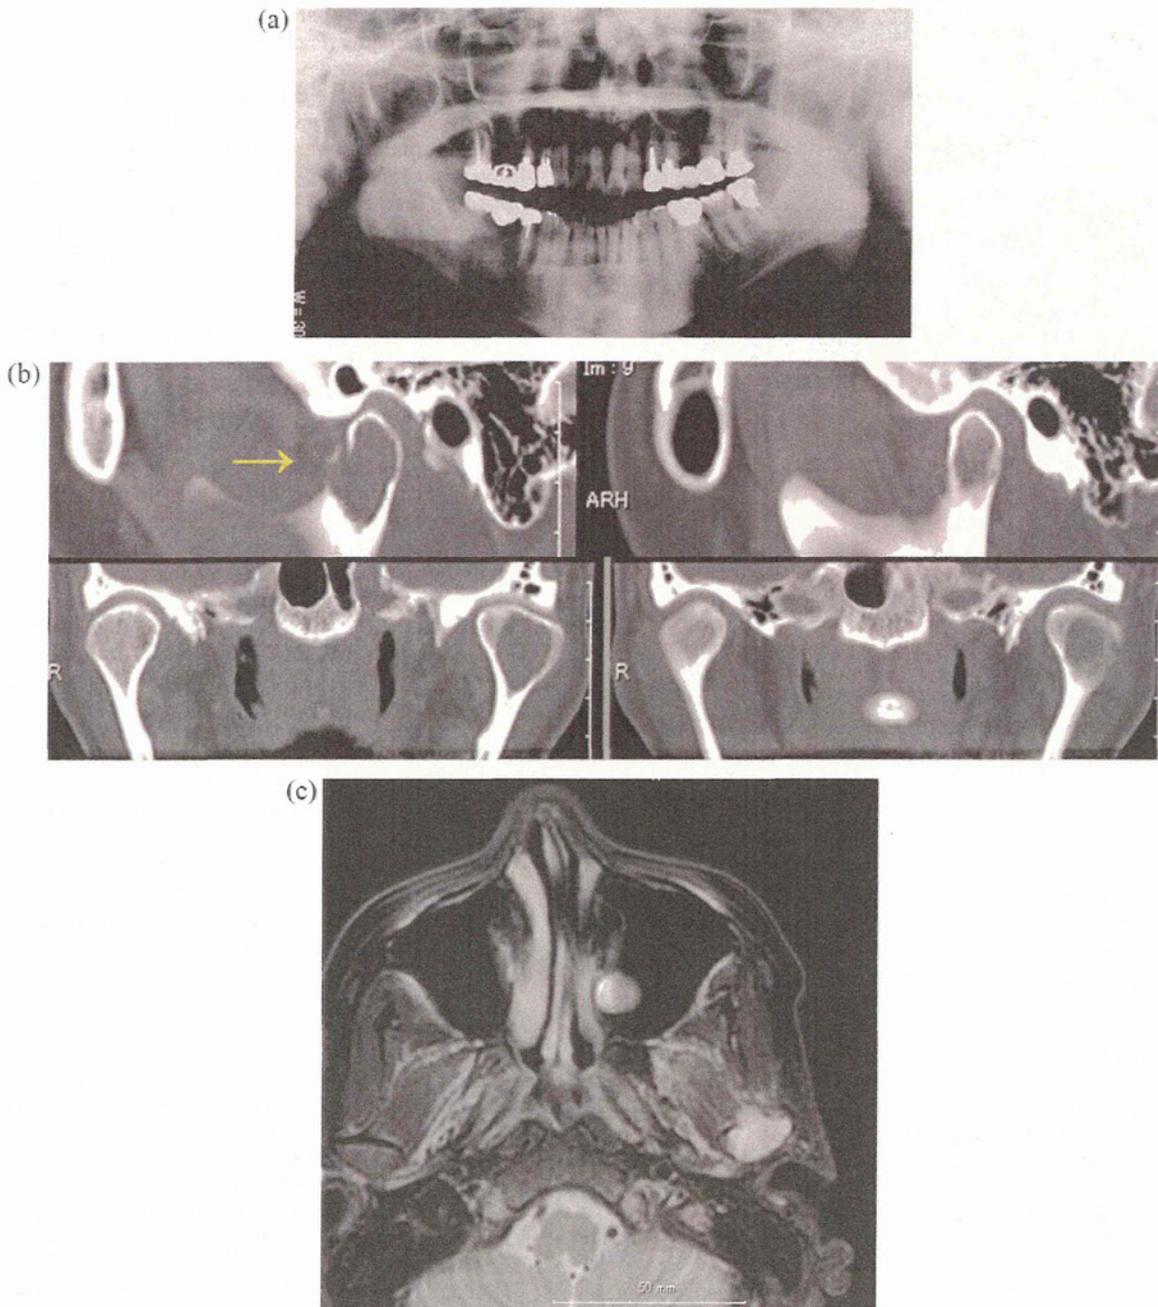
(a) Panoramic radiographs of the patient at first examination showing a radiolucent lesion in the mandibular condyle. (b) Coronal and sagittal CT (bone window setting) revealed osteolysis of the left mandibular condyle. (c) Axial and sagittal MRI (short time inversion recovery) revealed destruction of the left mandibular condyle and invasion of the lateral pterygoid muscle. (Hydrocele revealed in the left maxillary sinus.)
